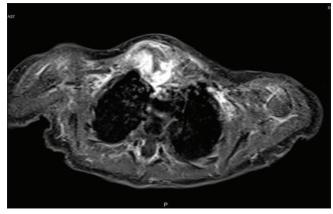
CT sternoclavicular joint
